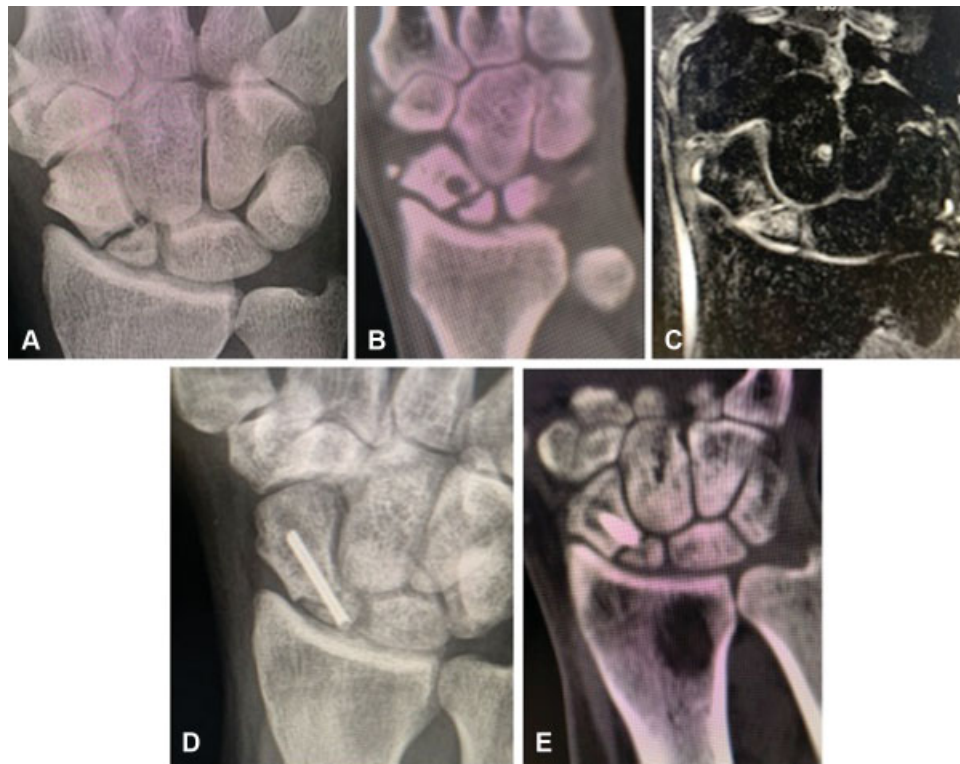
(A) PA preoperative radiographs showing proximal third scaphoid nonunion. (B) Preoperative CT scan of scaphoid nonunion showing cyst formation. (C) Preoperative MRI scan of scaphoid showing avascularity of proximal pole of the scaphoid. Four month postoperative radiograph (D) and CT scan (E) of scaphoid showing incomplete healing of the proximal third scaphoid nonunion. CT, computed tomography; MRI, magnetic resonance imaging.
